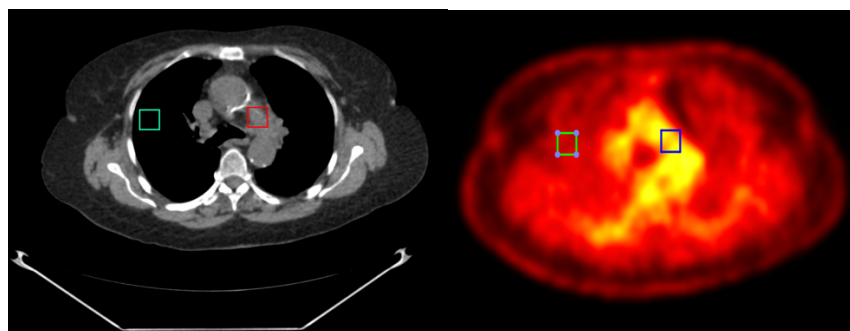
The reference CT and PET images for patient ROIs
